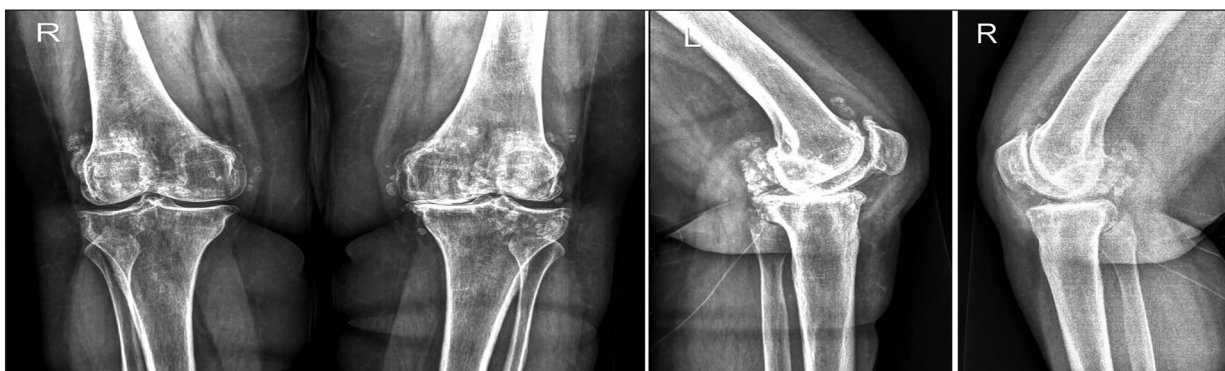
Postero-anterior and lateral X-rays of the knees demonstrating bilateral widespread multiple calcified loose bodies, joint space narrowing and osteoporosis.
